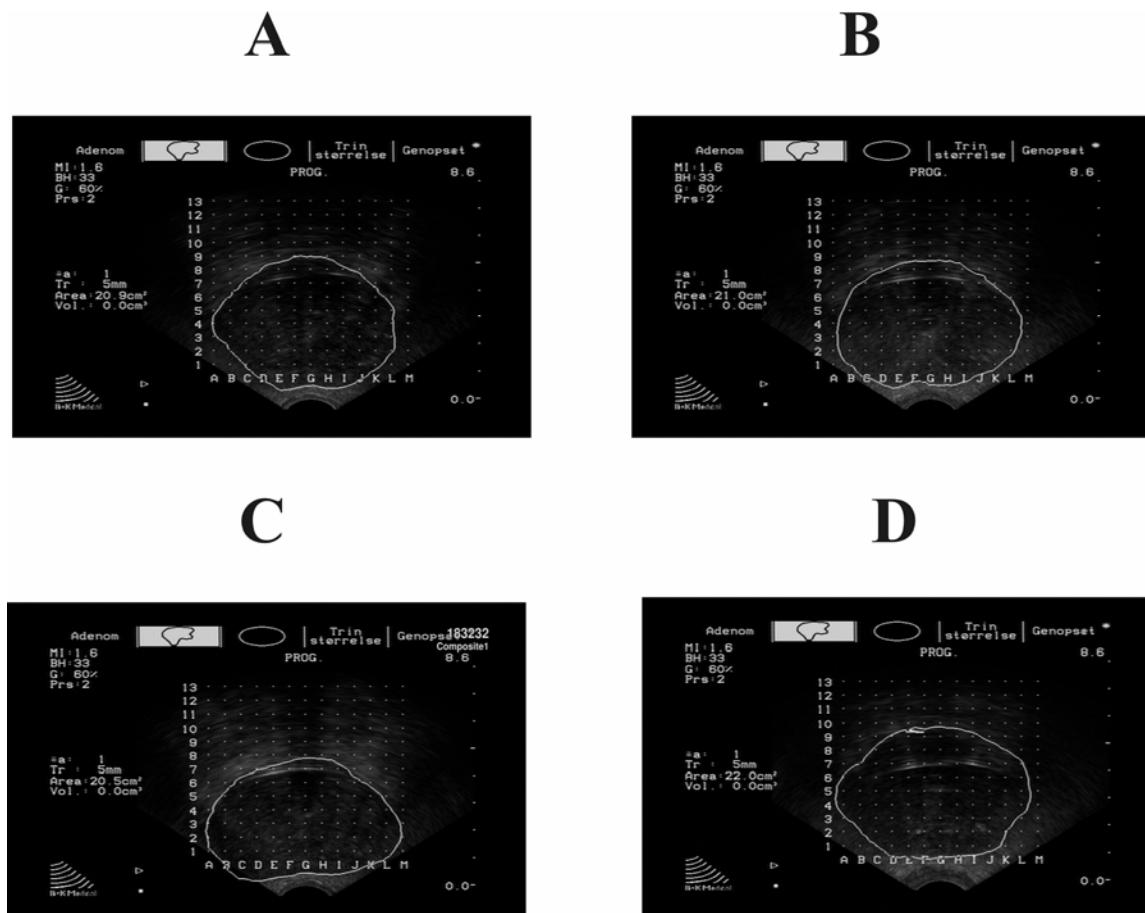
Representative two dimensional transrectal ultrasound (2D-TRUS) images of the prostate at the maximum axial cross section for the individual patient: A) phase I; B) phase II; C) phase III; D) phase IV.
